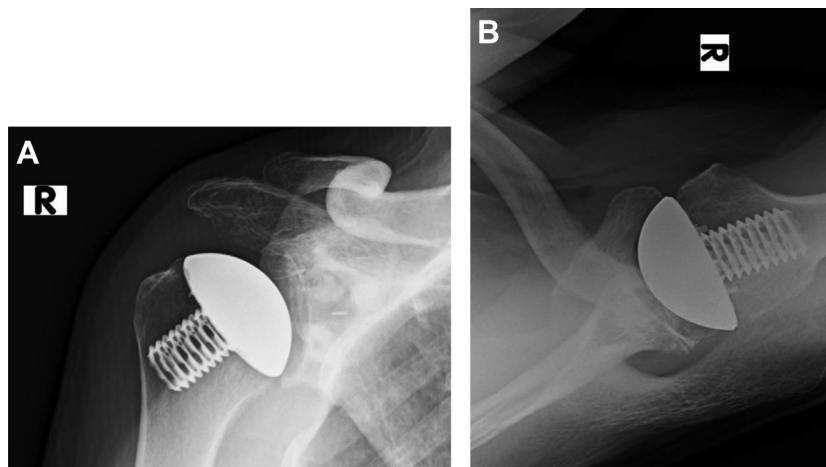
Postoperative Grashey (A) and axillary (B) radiographs showing excellent position of Eclipse shoulder prosthesis. Great care is taken not to overstuff the joint and to ensure that the cage screw does not engage the far humeral cortex. R, right.
